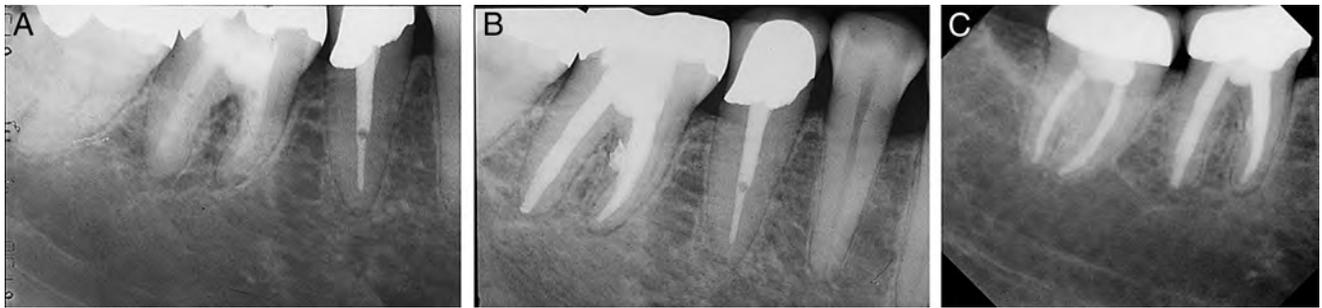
Case 9. (A) A preoperative radiograph of tooth #30 exhibiting an acute apical periodontitis. (B) A postoperative radiograph showing a strip perforation in the middle third of the mesial root. It was sealed with warm gutta-percha and Kerr Culp Canal Sealer (Sybron Endo, Orange, CA). (C) At the 9-year recall, the radiograph showed no evidence of endodontic disease. The tooth was asymptomatic and functional.
